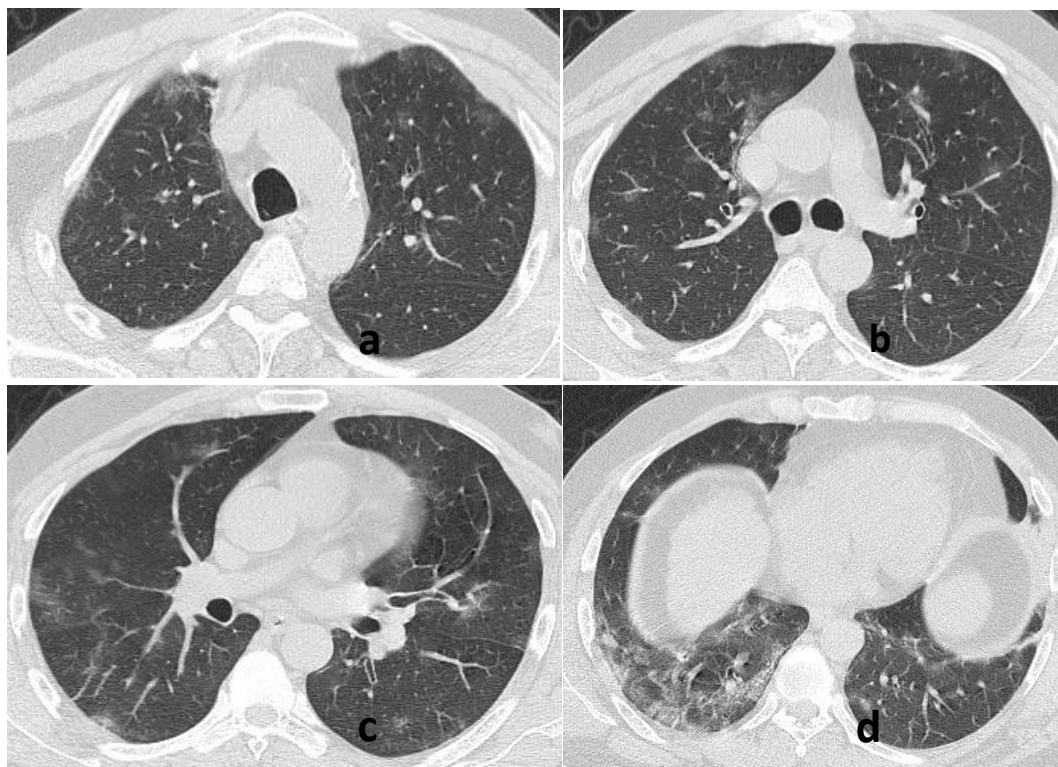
Axial chest CT non contrast images (lung window setting) in male of age 50 yr old who is COVID-19 positive patient. Multiple areas of ground glass opacities (GGO) involving the contralateral lung parenchyma predominantly in peripheral and basal areas are noted in this craniocaudal sequence (7 days following symptom start) (a, b, c, d).
